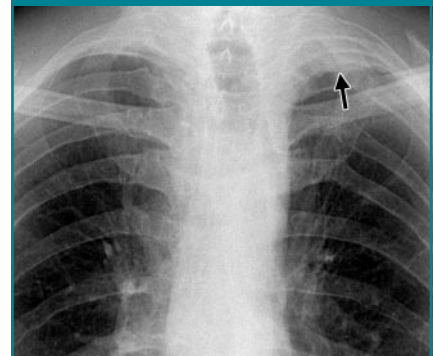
Magnified chest radiograph shows apical cap (arrow).
